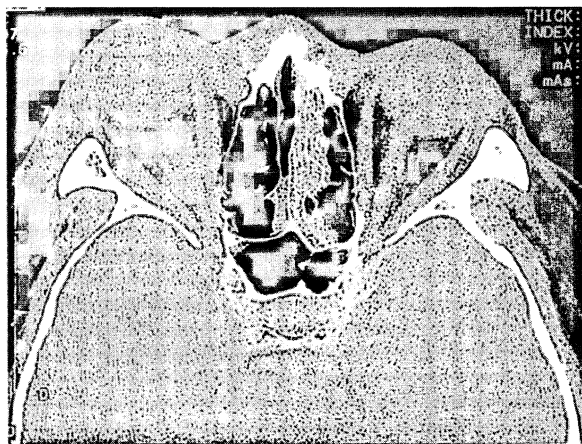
CT scan showing proptosis right globe without retrobulbar mass
